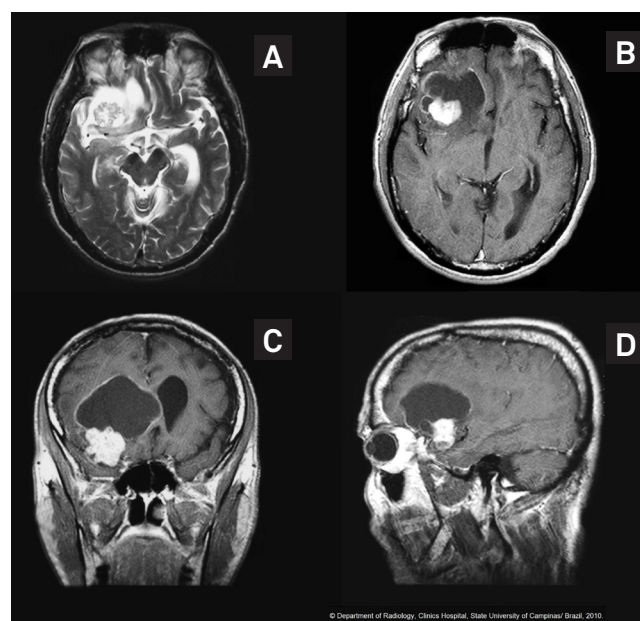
Male, 63 years old. (A) Contrast-enhanced axial T2-weighted magnetic resonance (MR) image shows a frontal expansive solid-cystic lesion, with lobulated delineation. Cystic component shows hyperintensity. Contrast-enhanced axial T1-weighted MR image (B), coronal (C) and sagittal (D) shows enhancement in the solid component and at the periphery of the cystic component.
